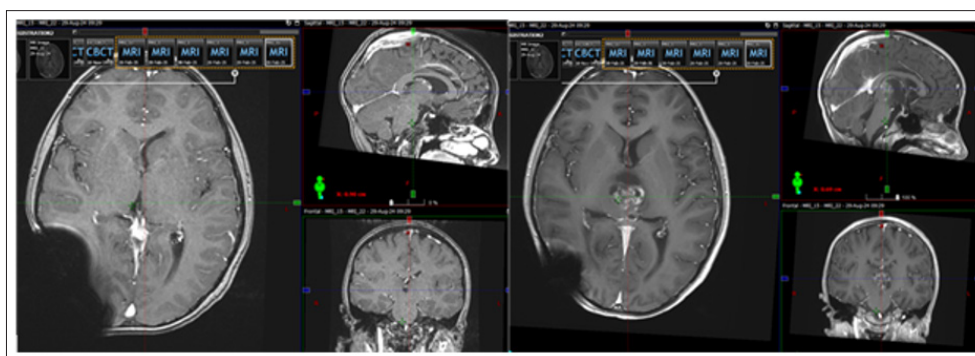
The Comparison of the MRI 3 Months after the Completion of Local IMRT with the MRI Image before the Operation.
